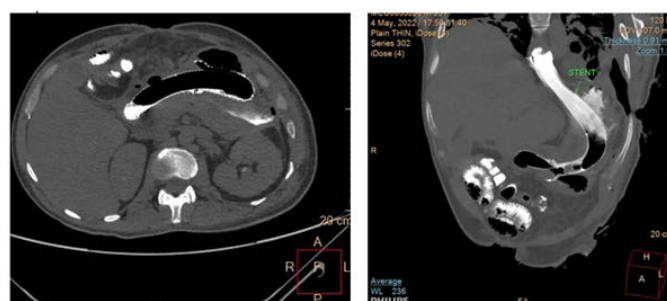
CT image shows stent-in-stent from esophagus to duodenum, with minimal extravasation of contrast through the gastric defect, in A) Axial and B) Sagittal views.
